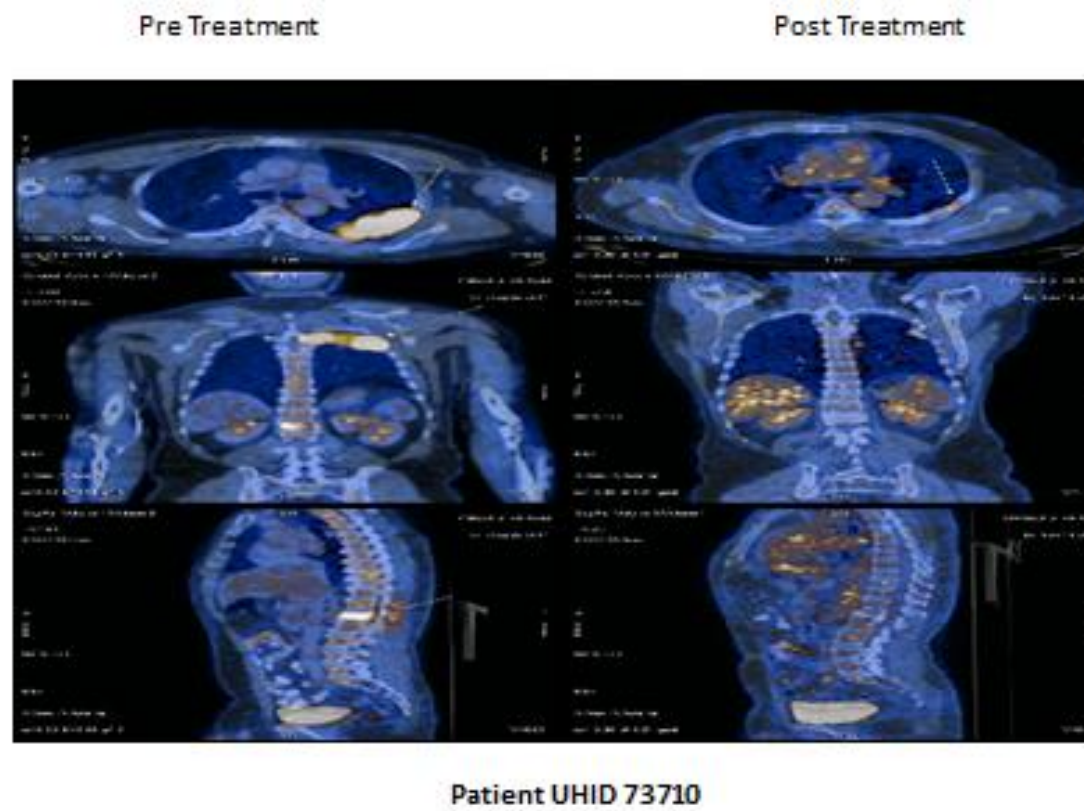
Pre treatment and Pre transplant PET CT Scans
